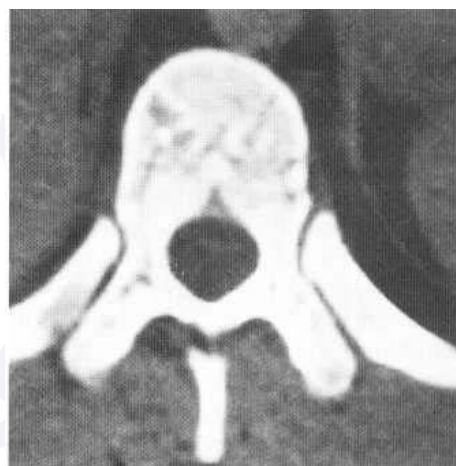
Normal dorsal vertebral, CT axial section. Normal defects in the cortex of the vertebral body for the passage of the veins are shown; the posterior defect is for the basivertebral veins. Note the circular spinal canal with equal sagittal and coronal diameters.
